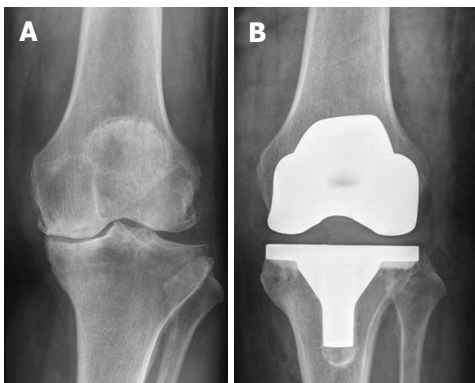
Anterior-posterior radiograph of a left knee of a female patient. A: Preoperative severe osteoarthritis; B: Postoperative with the Sigma CR, total knee arthroplasty (Depuy) *in situ*.
